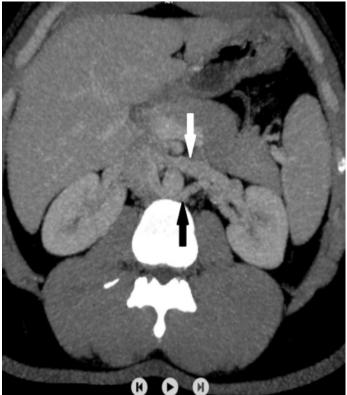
Axial CT image of the anterior branch (white arrow) and posterior branch (black arrow) of the circumaortic left renal vein
